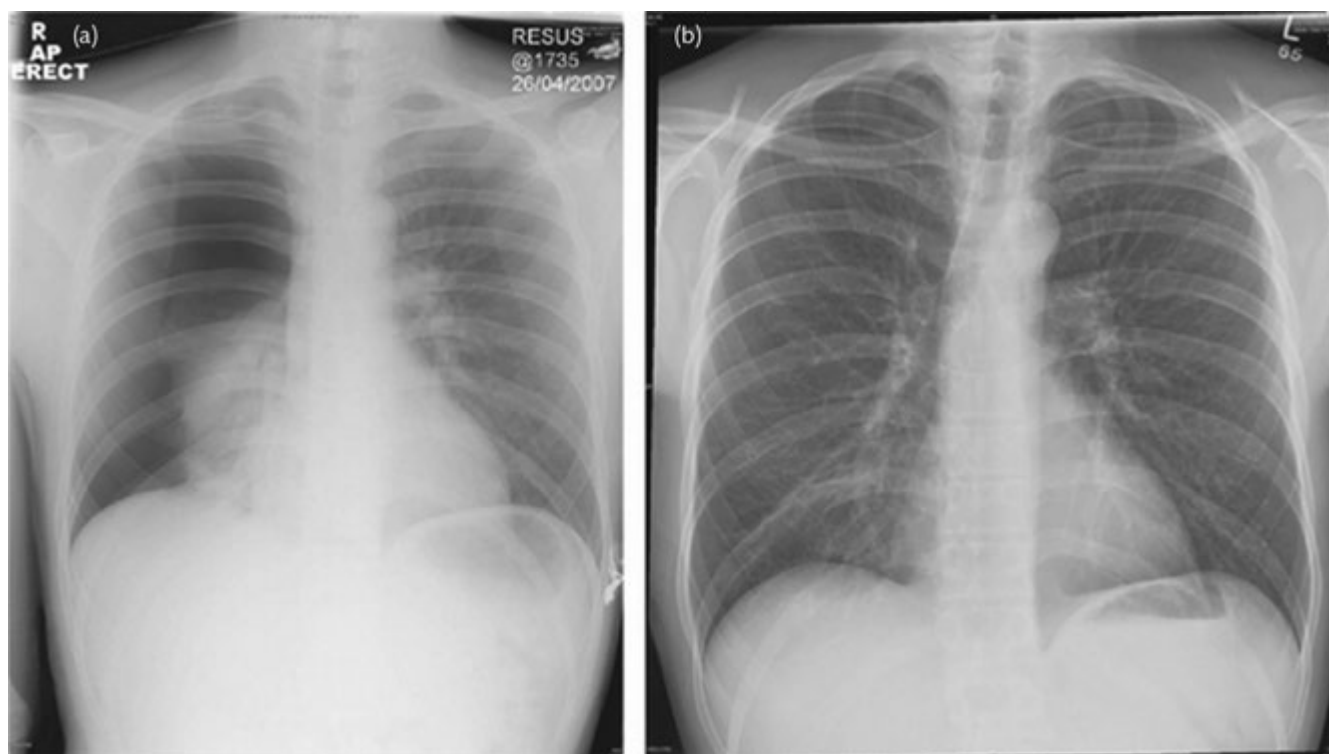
Chest radiographs showing a primary spontaneous pneumothorax before (a) and after (b) successful pleural aspiration.
